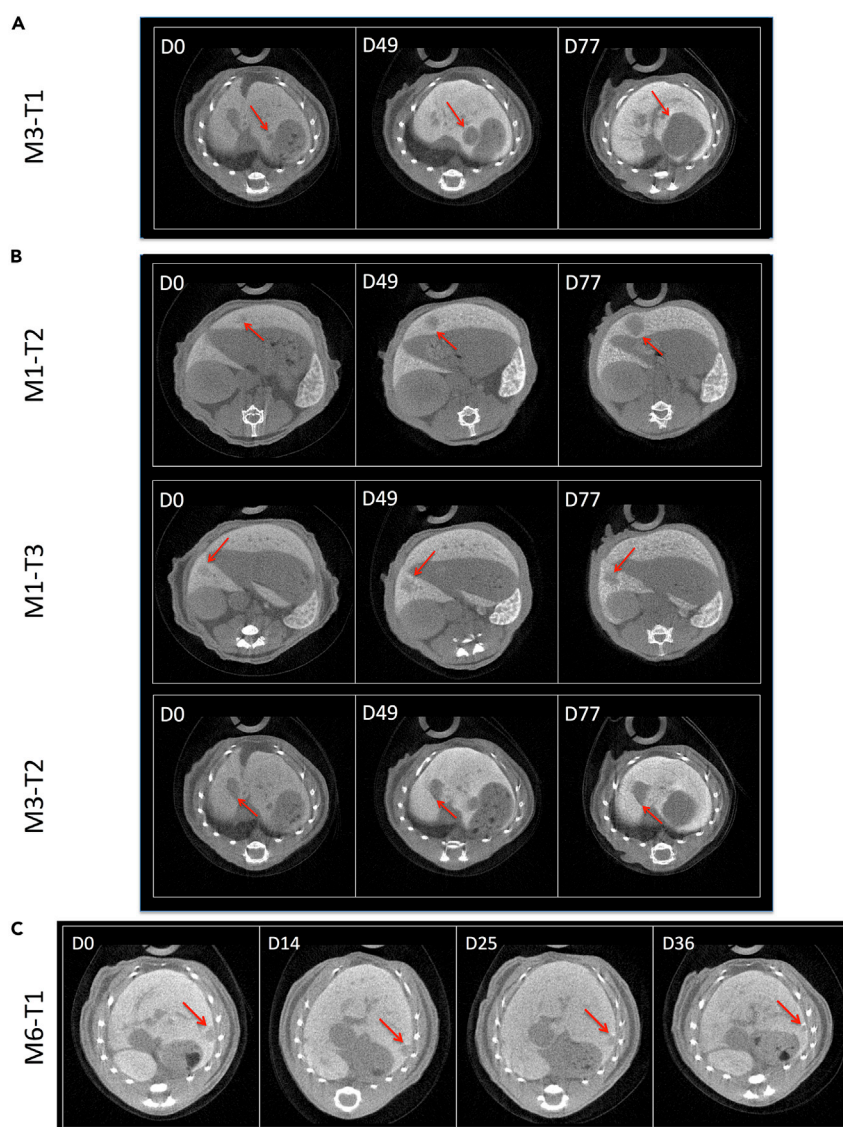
Detection of Liver Tumors Starting from $0.5 \times 10^{-2} \text{ cm}^3$ of Tumor Volume and Assessment of Their Evolution with the PIXSCAN-FLI PC-CT Prototype
